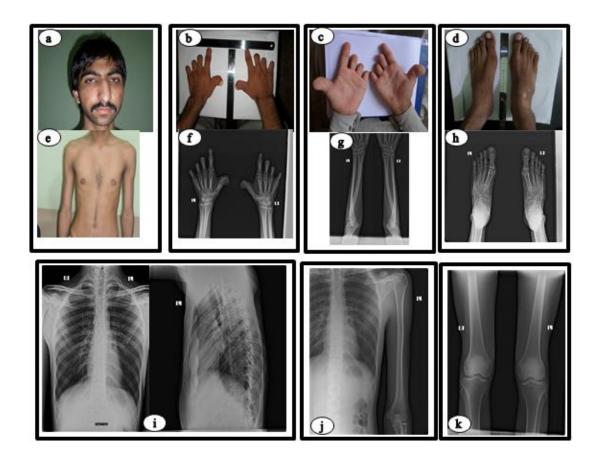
The photographs and radiographs of the subject with type B1 brachydactyly
